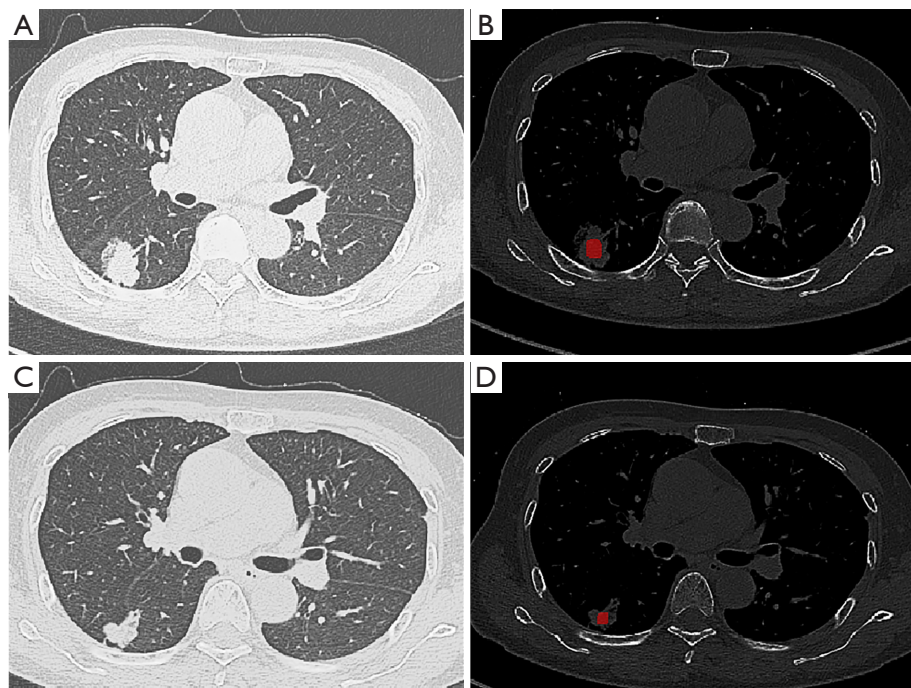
RadiAnt extracts cross-sectional CT images. (A) A solid nodule was discovered on slice 90 (Im90) from the initial CT examination in June 2020 of a 60-year-old male patient. (C) A solid nodule was discovered on slice 98 (Im98) from the same CT examination of the same patient. (B) The red region indicates the ROI delineated on slice 90 on the mediastinal window (window width: 350 HU, window level: 50 HU). (D) The red region indicates the ROI delineated on slice 96 on the mediastinal window (window width: 350 HU, window level: 50 HU). CT, computed tomography; ROI, region of interest.
